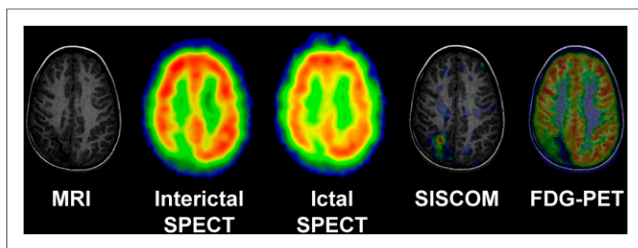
Multimodal neuroimaging studies of patient 8, a 9-y-old boy with drug-resistant complex partial seizures. MR imaging shows right parietal encephalomalacia, with concordant hypoactive zone in interictal SPECT and ^{18}F -FDG PET studies that were classified as not localizing. Ictal SPECT showed subtle hyperperfusion that was clearly depicted by SISCOM in area adjacent to malacia.
